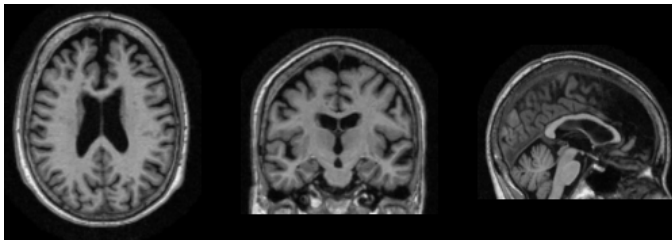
An example of MRI scan from OASIS-3 [32]. From left to right, the figures show the axial, coronal and sagittal views.
